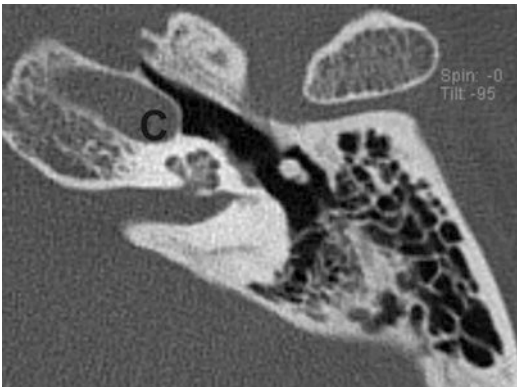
Axial temporal bone CT revealing mineralization within the cochlea consistent with labyrinthine ossificans (c carotid canal)
